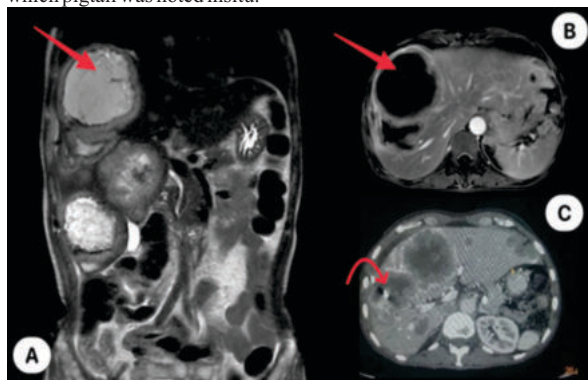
reveals coronal T2 (A), axial post contrast (B) and post contrast CT images showing multiple round to oval shaped lesions in both lobes of liver, with internal cystic areas within suggestive of metastases. In image C, there is a hyperechoic foci (curved arrow) representing the pigtail insitu.
